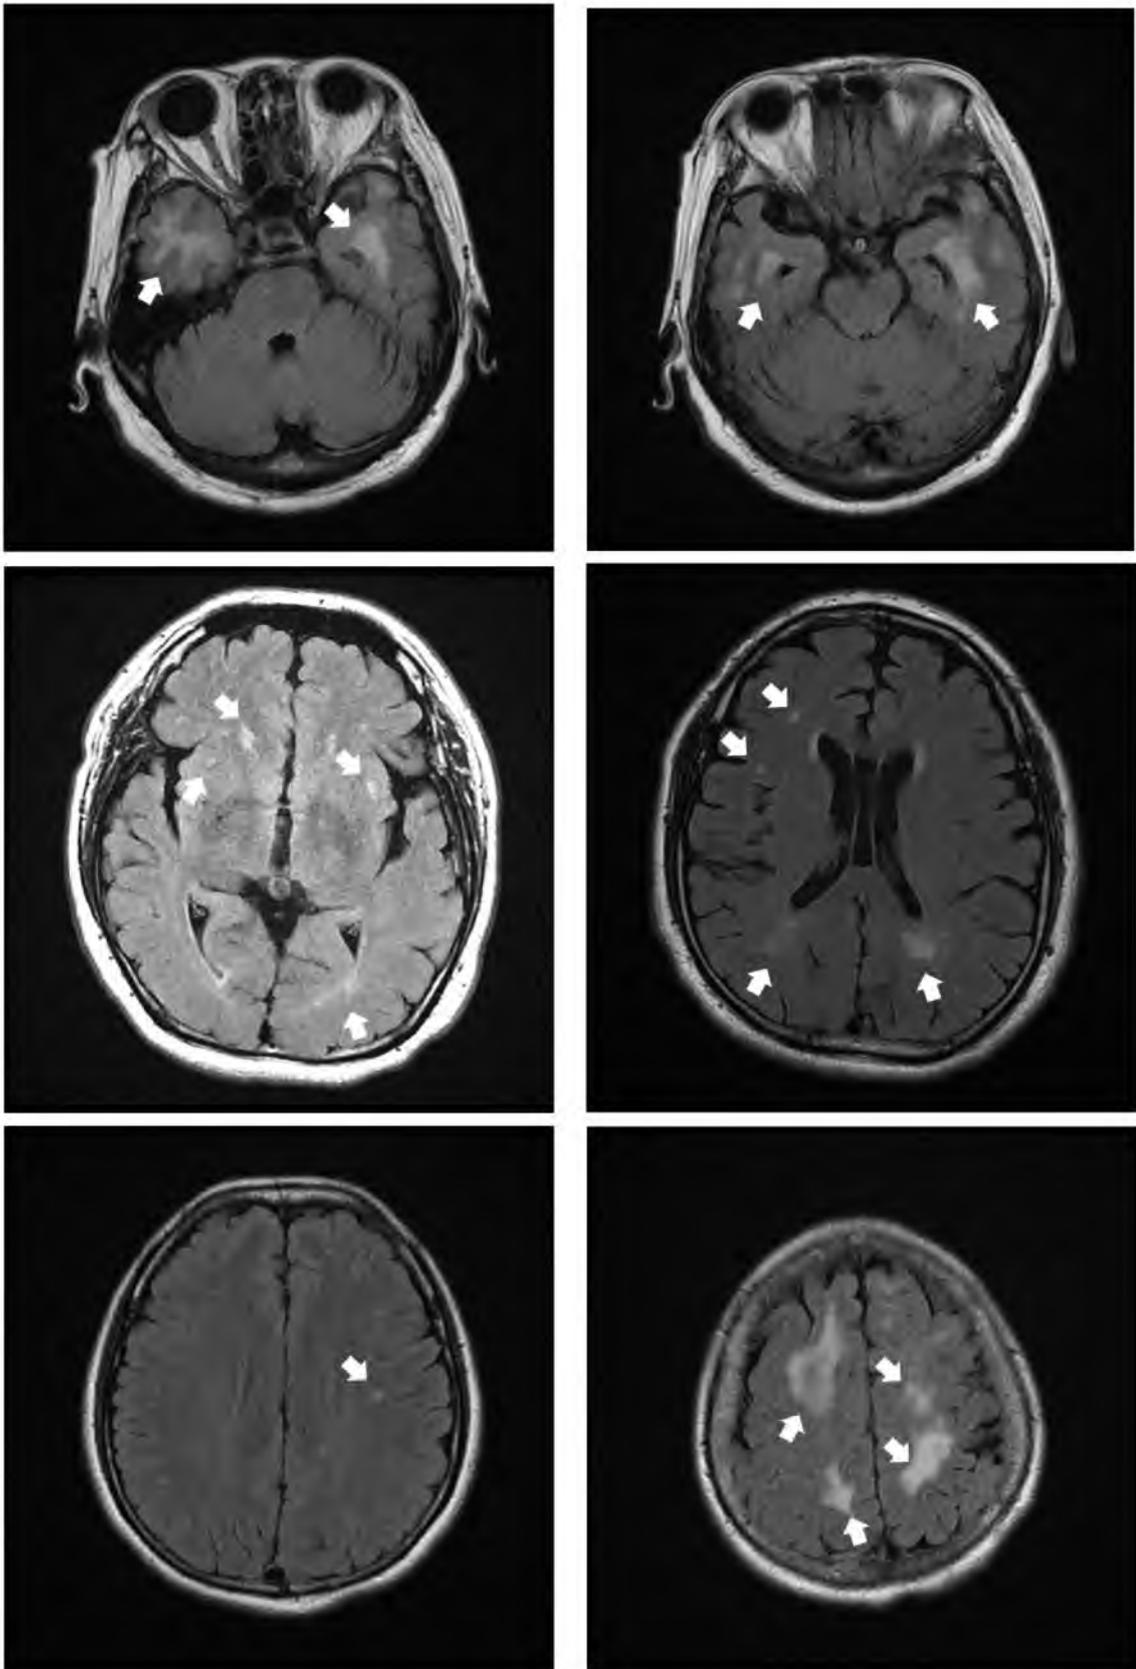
FLAIR MR Images (axial view) on 1.5T MRI scans. Arrows indicate the presence of lesions.
